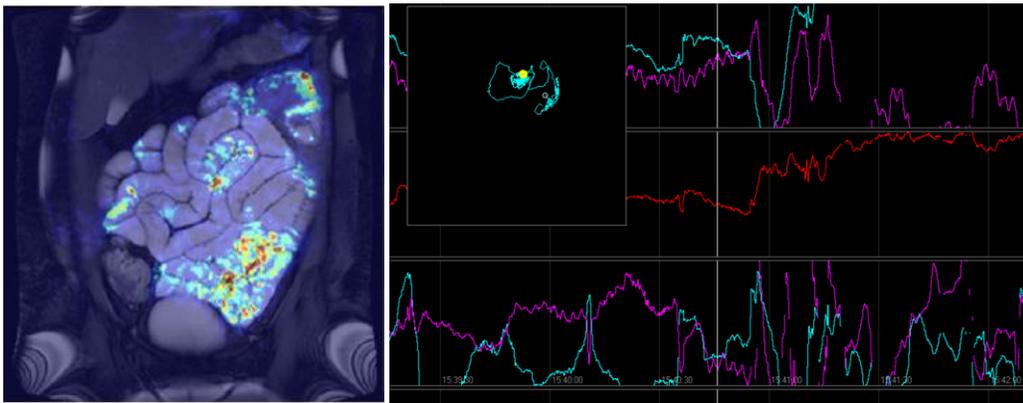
To the left, assessment of small bowel motility using MR images. To the right, a screenshot from a MTS-2 recording. Purple and blue lines indicates rotation and propulsion of the MTS-2 capsule providing insides of gut motility.
